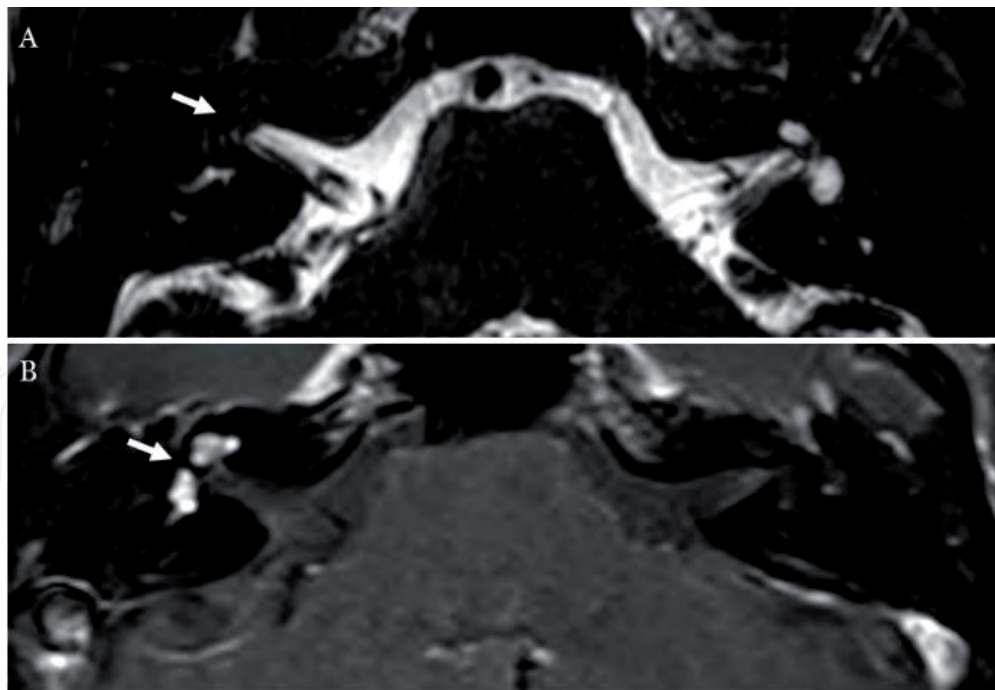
MR images 3D-T2 (A) showing reduced T2 signal of the right cochlea and vestibule (arrow); after intravenous contrast-medium administration T1w sequence (B) shows cochlear and vestibular enhancement (arrow), due to intralabyrinthine schwannoma.
